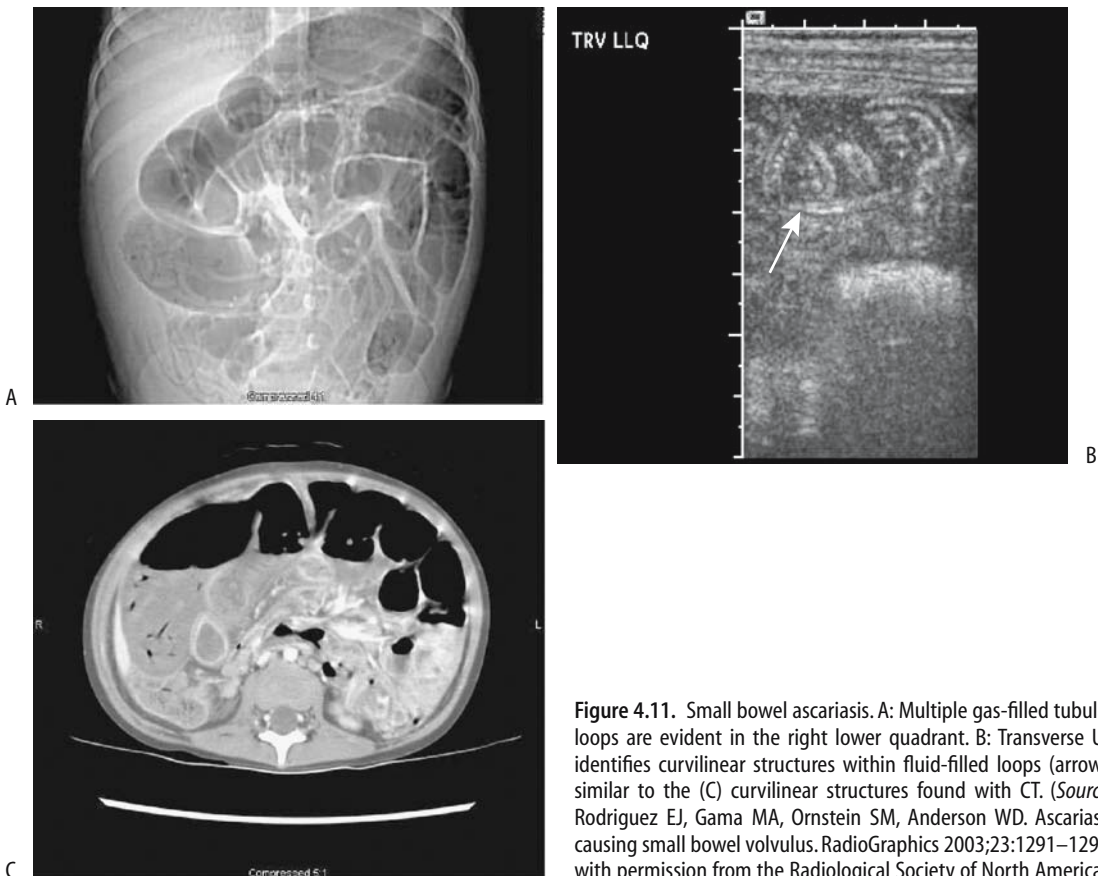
Small bowel ascariasis. A: Multiple gas-filled tubular loops are evident in the right lower quadrant. B: Transverse US identifies curvilinear structures within fluid-filled loops (arrow), similar to the (C) curvilinear structures found with CT. (Source: Rodriguez EJ, Gama MA, Ornstein SM, Anderson WD. Ascariasis causing small bowel volvulus. *RadioGraphics* 2003;23:1291–1293, with permission from the Radiological Society of North America.)
